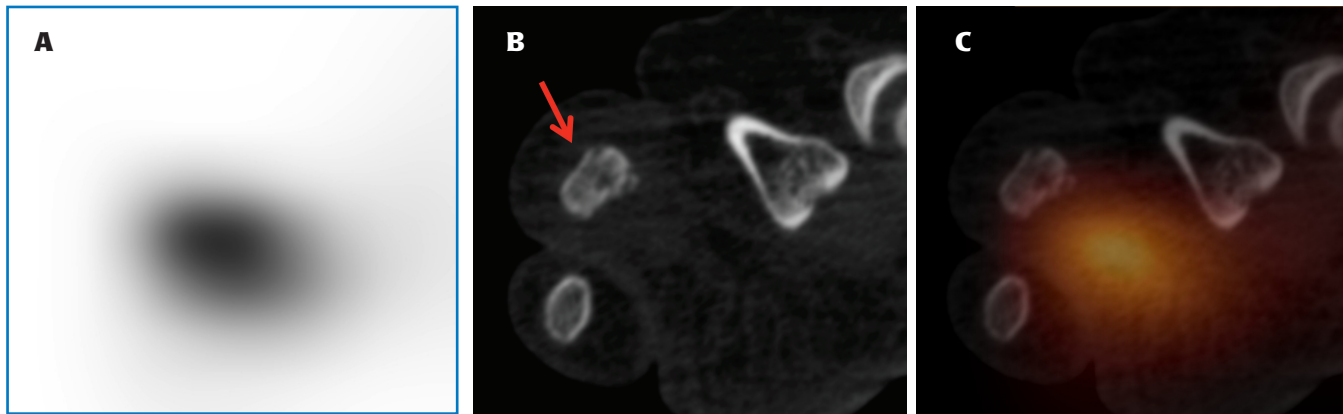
SPECT/CT images demonstrate intense focal tracer activity in the proximal right fourth toe with a nondisplaced fracture in the distal aspect of the right fourth proximal phalanx.
